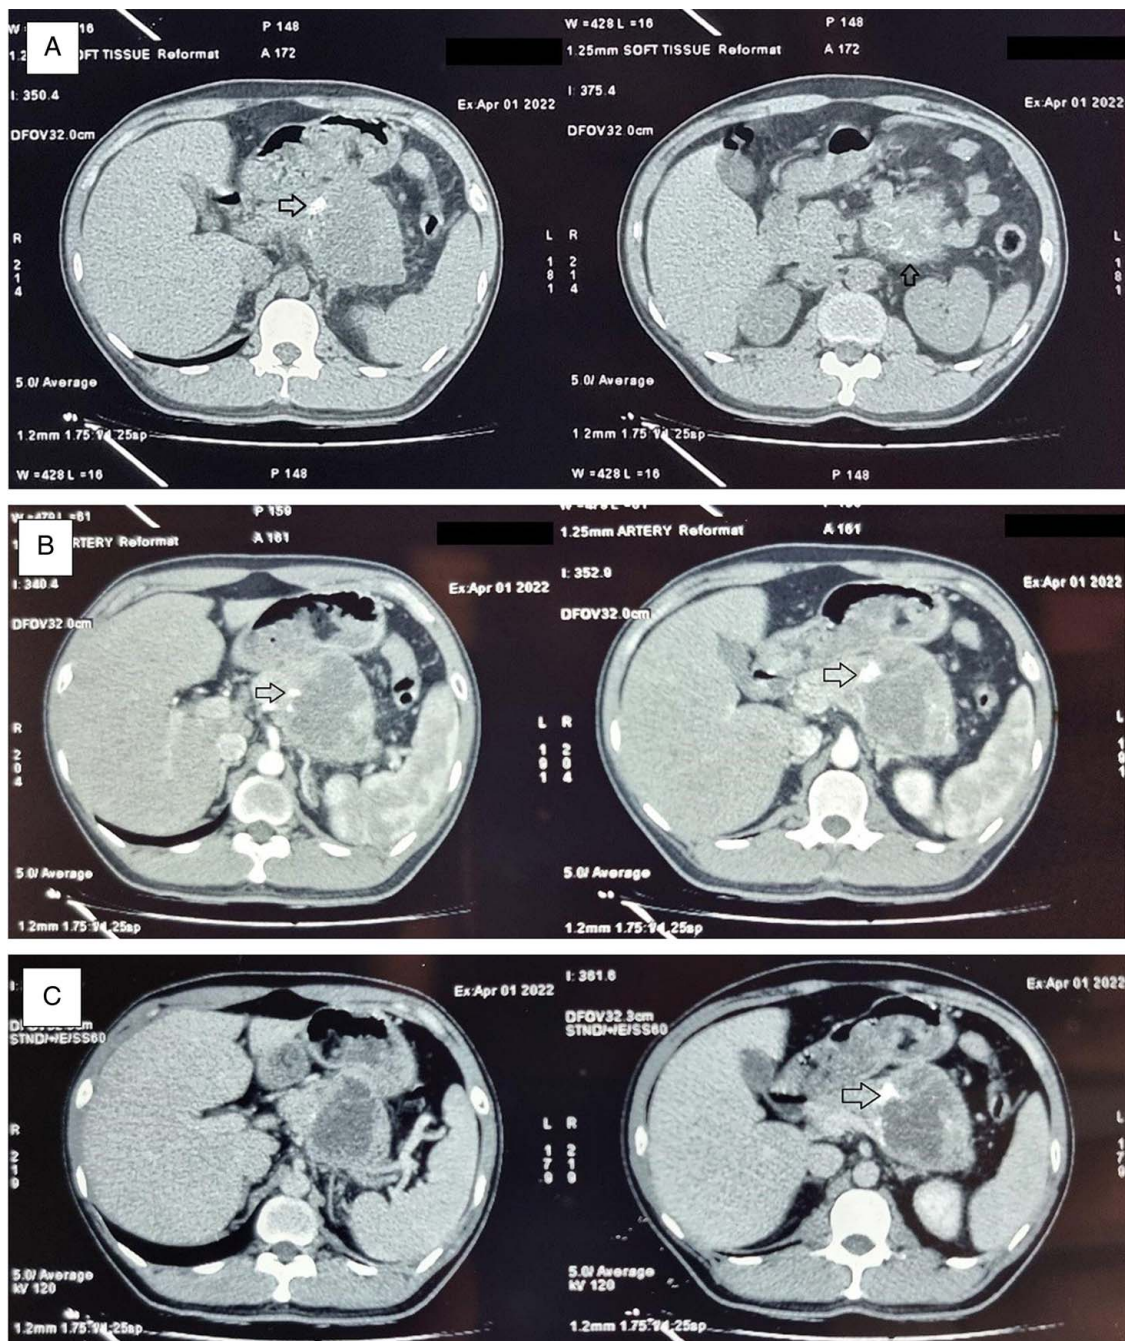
Axial pre-contrast (A) and post-contrast arterial phase (B) and venous phase (C) computed tomography.
